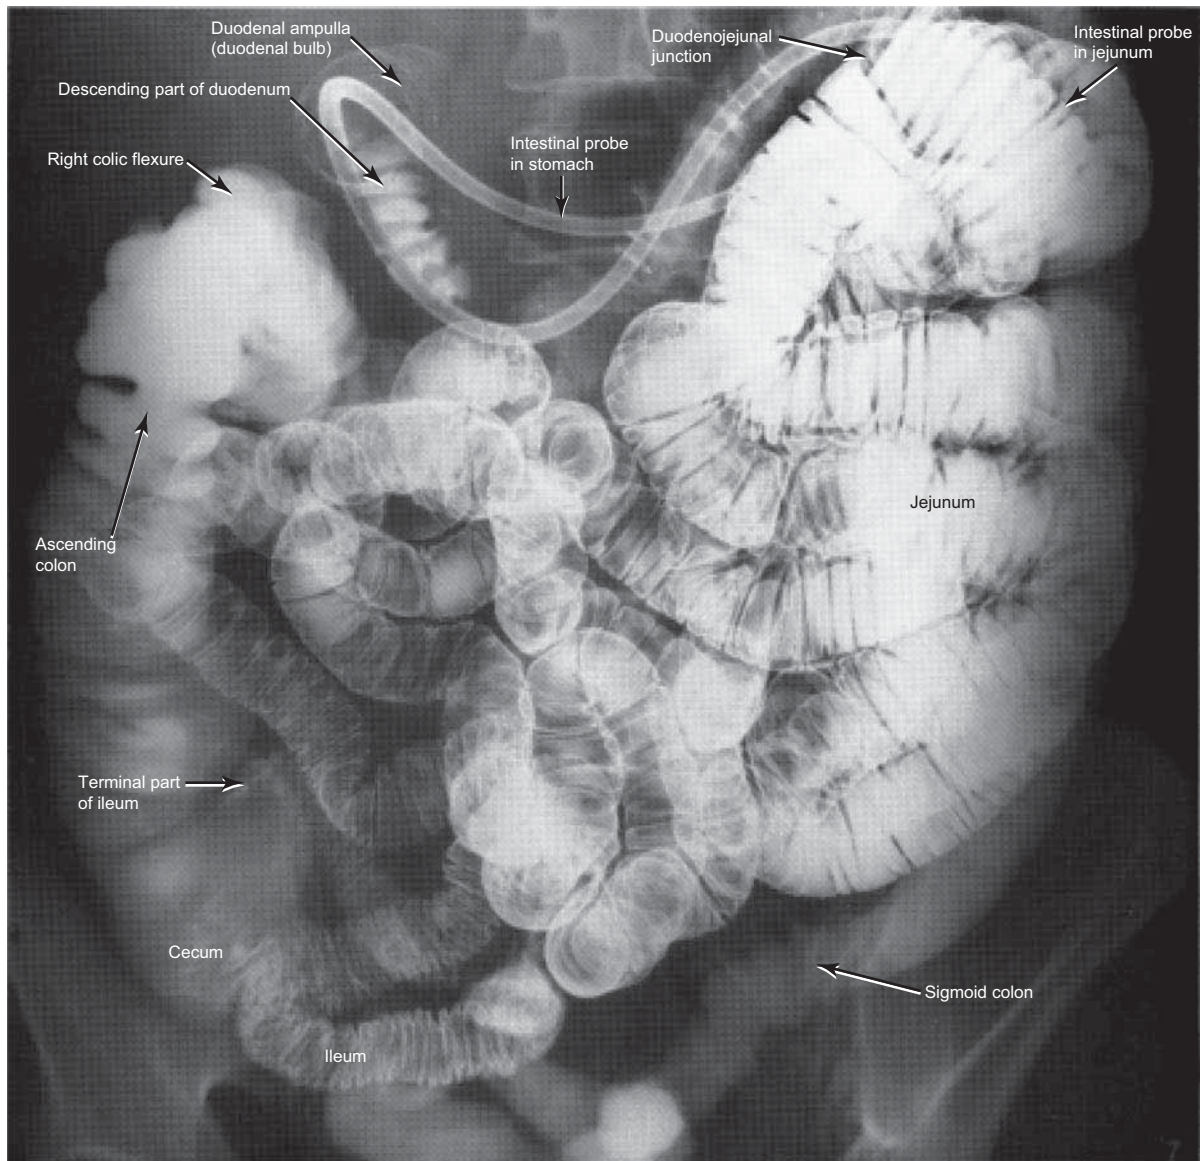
Radiograph of the Jejunum, Ileum, Cecum, and Ascending Colon
